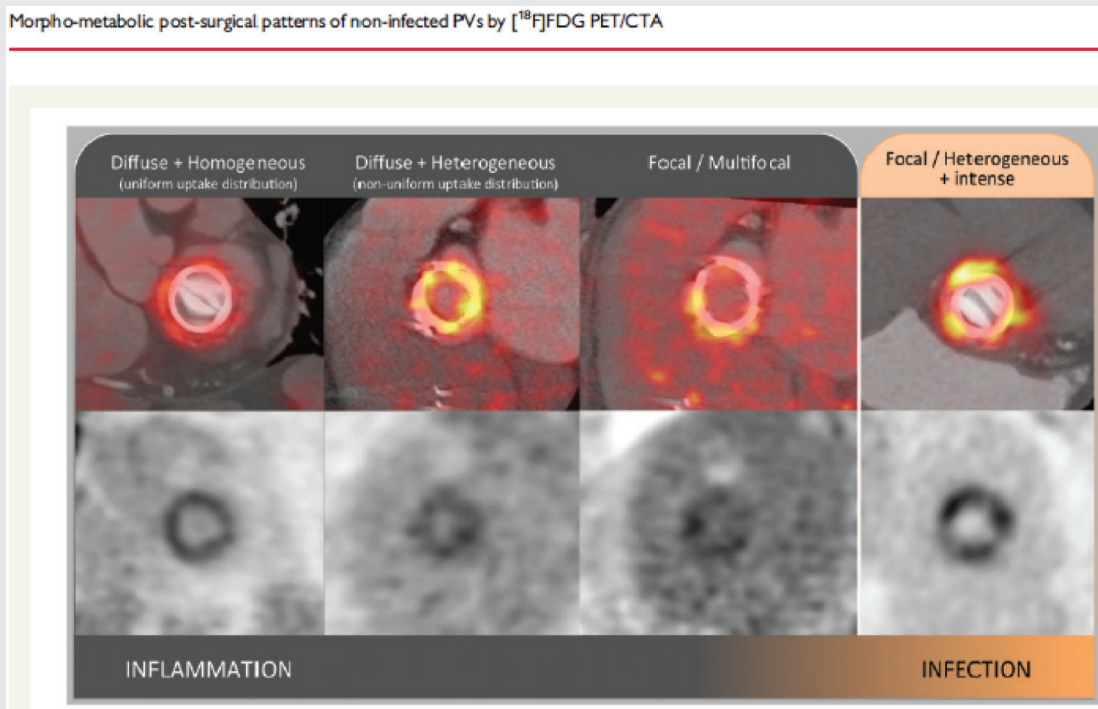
18F-fluorodeoxyglucose uptake distribution patterns (visual assessment). 18F-fluorodeoxyglucose uptake in non-infected prostheses (left panel), compared with an example of prosthetic valve endocarditis (right panel). Positron emission tomography/CTA fusion images of the valve plane (upper row), and their corresponding attenuation-corrected positron emission tomography images (lower row). From left to right, the characteristic inflammation patterns in order of descending frequency: diffuse homogeneous (93%), diffuse heterogeneous (7%), and focal/multifocal (2%). The diffuse homogeneous pattern is characteristic of inflammation and clearly differentiable from infection, whereas more focal. 18F-fluorodeoxyglucose uptake may overlap with infective endocarditis. No anatomic lesions were detected in any patient. Reproduced with permission from Roque et al.⁴⁴
